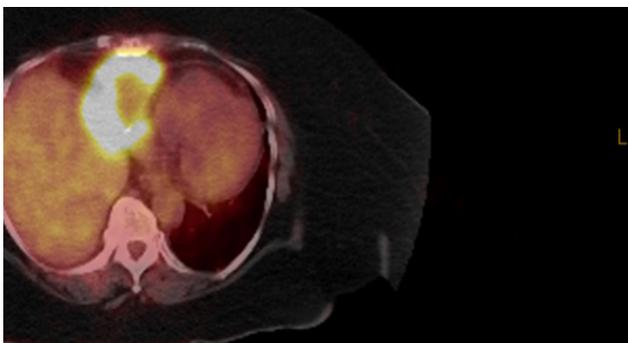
Comparison of pre-treatment PET/CT (left) and post-treatment PET/CT (right)
